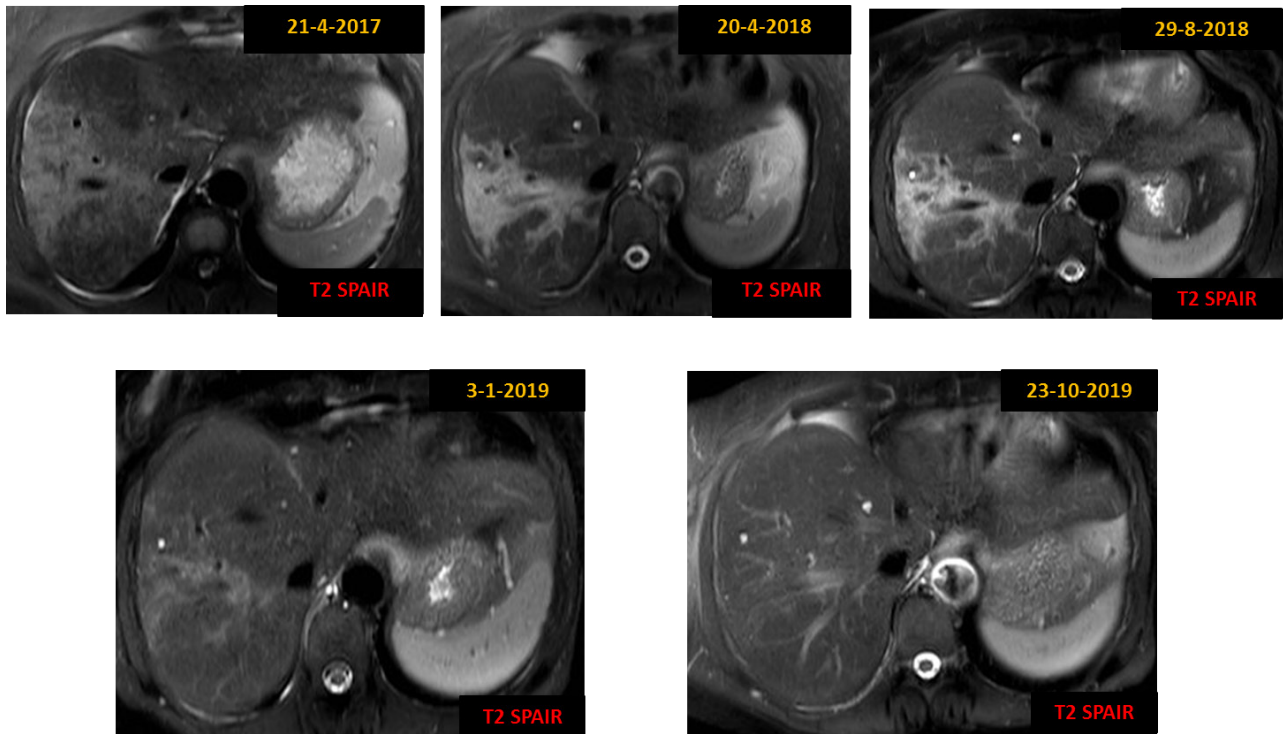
Fat-saturated T2WI in a 48-year-old patient with autoimmune hepatitis proven on biopsy. Consecutive MRI exams at approximately the same level of the right liver lobe show a wedge-shaped area of high signal intensity without any mass effect. Vessels cross the area without any distortion. There is gradual reduction of the lesion's size followed by complete remission.
